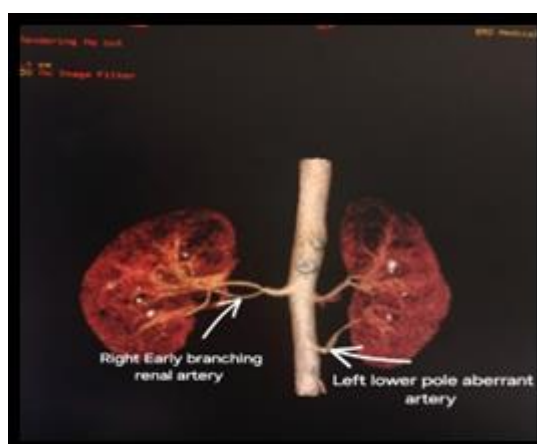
Computed tomography arterial phase images showing left lower pole aberrant renal artery with right early branching renal artery
